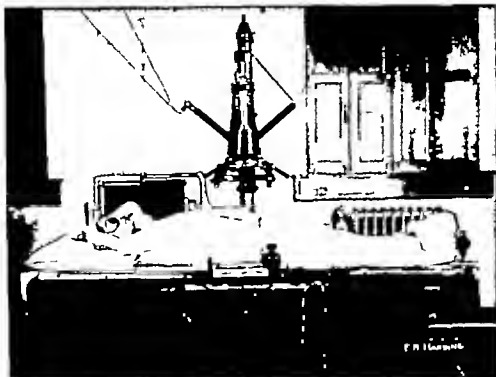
Patient in position upon radioscopic table prior to obtaining stereo-roentgenograms.
